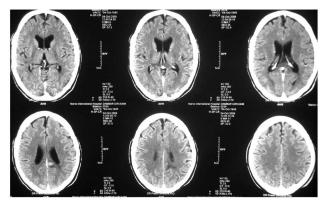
CT scan of brain showing almost complete resolution of the lesions after steroid therapy
